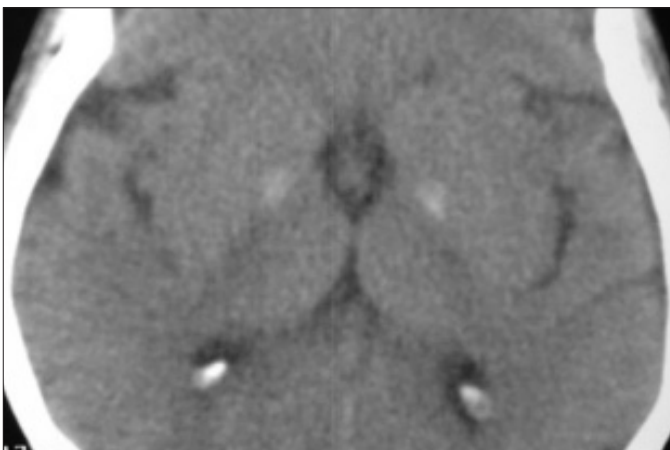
Axial CT image shows bilaterally symmetric calcification of the globus pallidum
